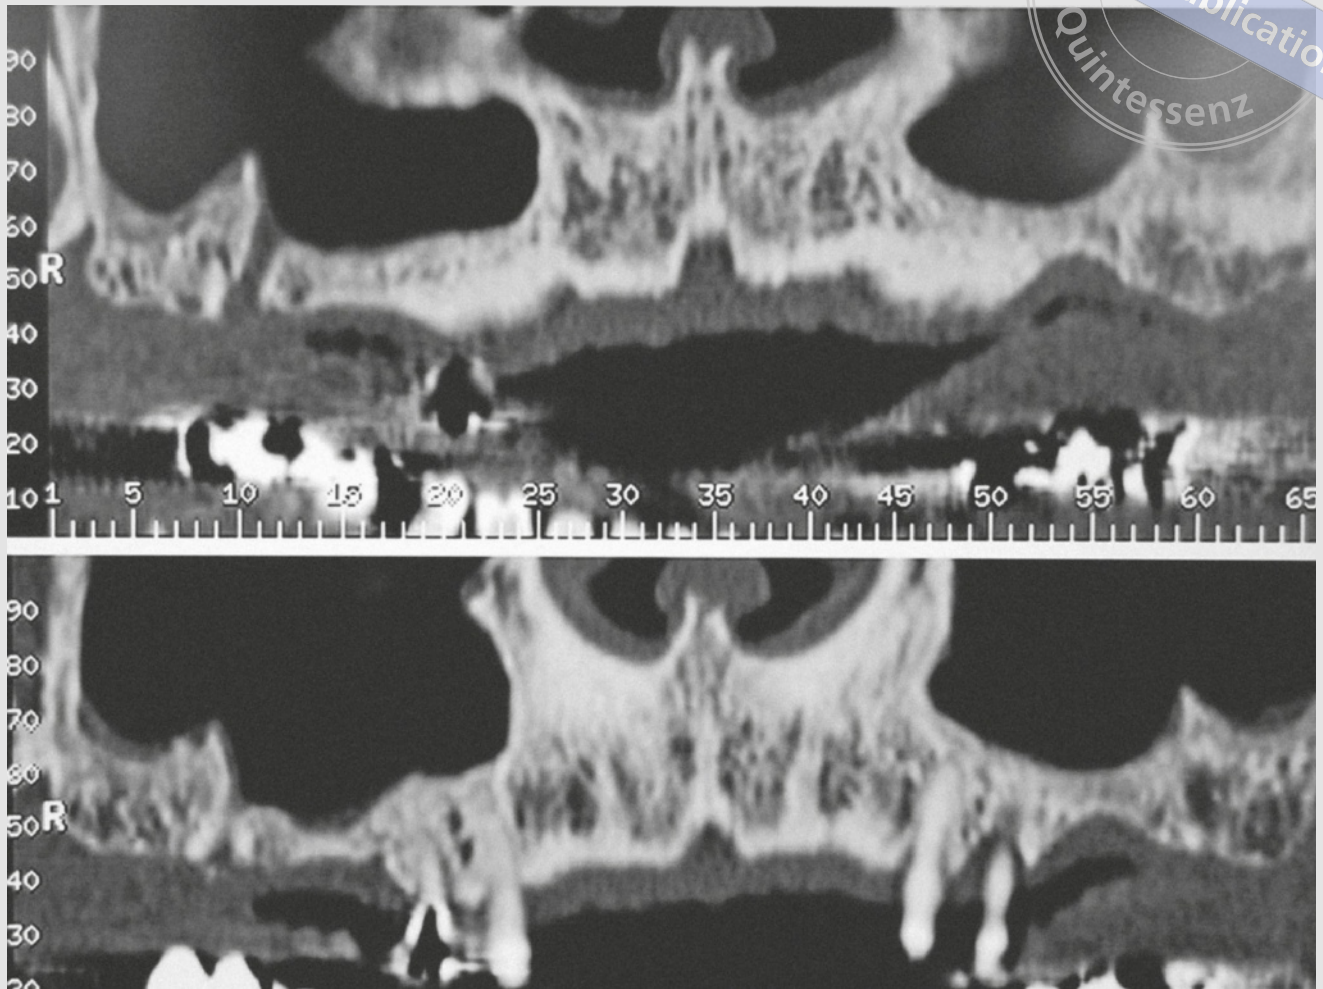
Initial view of the maxillary sinus (CBCT panoramic sections).
